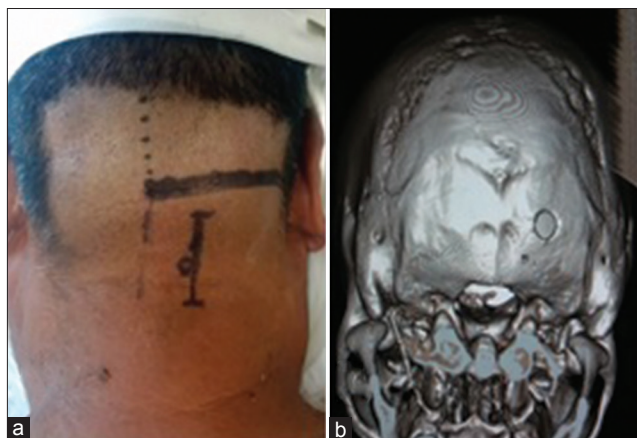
(a) The surgical planning with the vascular anatomic structures in the posterior fossa. (b) 3D reconstruction of CT scan with burr hole at the occipital bone
